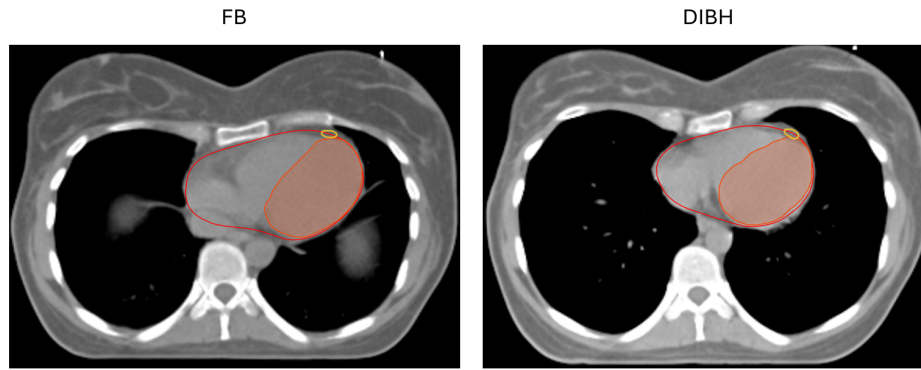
CT images with contours generated by Limbus AI software for the heart (red contour), LV (orange contour), and LAD (yellow contour) of a patient in both DIBH and FB conditions.
